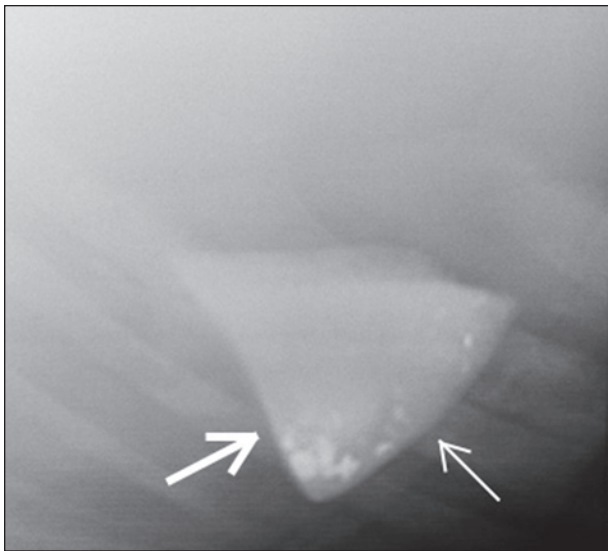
Same radiographic view as in Figure 1. Notice the cranioventral (thin arrow) and caudoventral (thick arrow) borders of the sand conform to the most dependent aspect of the colon.
